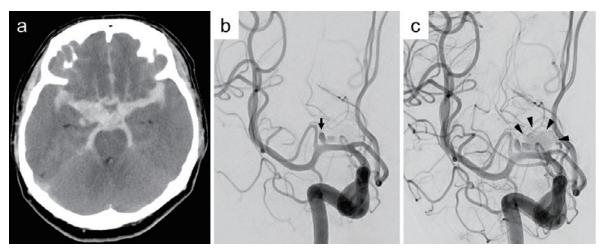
(a) Noncontrast head computed tomography showing diffuse subarachnoid hemorrhage at onset. (b) Right internal carotid angiogram, anteroposterior, demonstrating a right middle cerebral artery saccular aneurysm (arrow). (c) Right internal carotid angiogram, delayed phase, presenting a pseudoaneurysmal cavity (arrowheads) connected to the right middle cerebral artery aneurysm.
